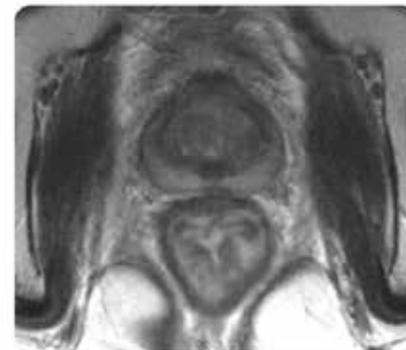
SpaceOAR Clinical Trial Patient, MRI Images : Normal Anatomy, During Prostate RT and 6 months Following
